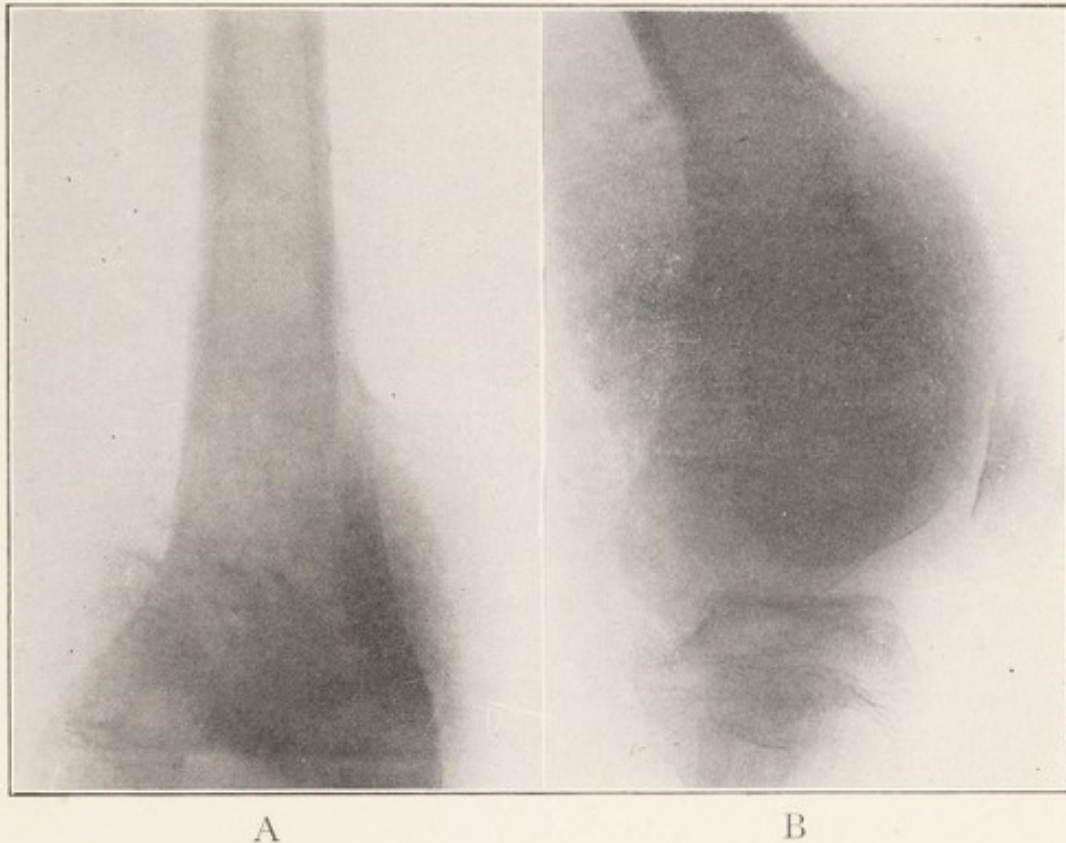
X-RAY OF PERIOSTEAL SARCOMA OF LOWER END OF FEMUR, ANTEROPOSTERIOR VIEW.
